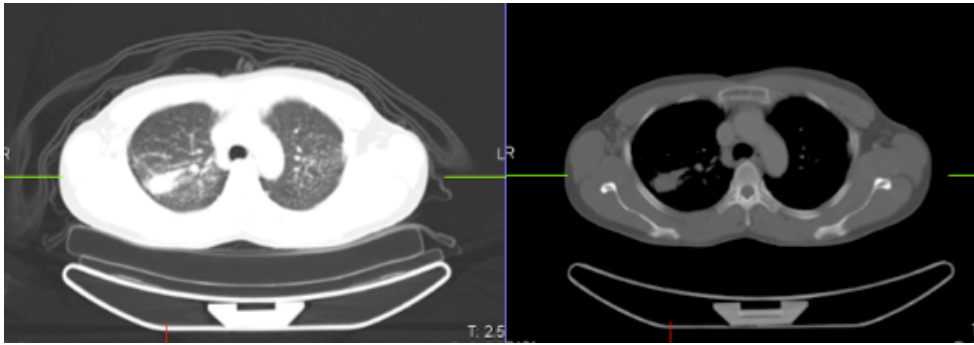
A contrasted CT was performed, which demonstrated a dense opacity in the posterior segment of the Right Upper Lobe (RUL). A spiculated border and contrast enhancement (70→110 HU) of the lesion, lead to the conclusion that a malignant process could not be excluded. Para-tracheal lymph nodes were also noted.
